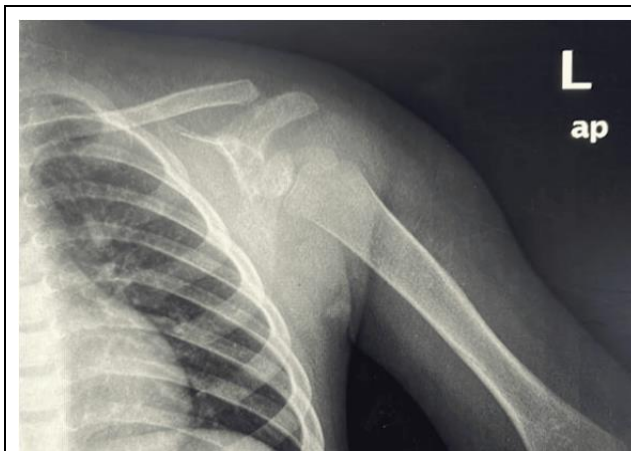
Left shoulder Anteroposterior radiograph revealed normal bony signal of the left shoulder joint, clavicle, scapula, and left proximal humerus.
